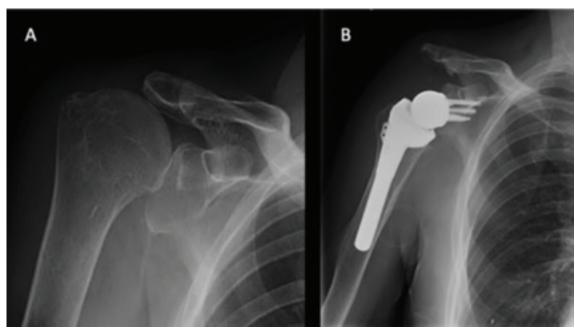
Reverse Total Shoulder Arthroplasty. (A) A radiograph of rotator cuff tear arthropathy; (B) A radiograph of reverse shoulder arthroplasty. (Surgeon: John Kelly)
